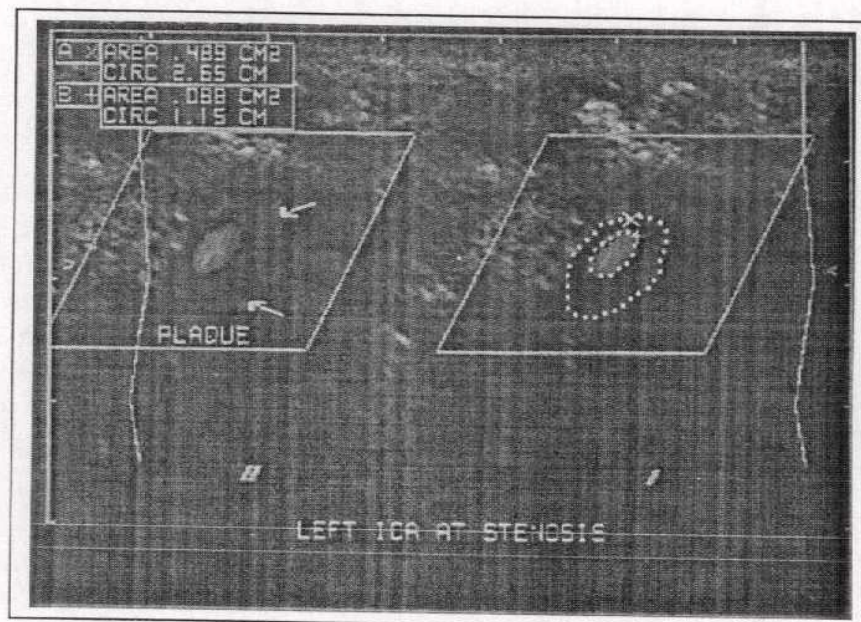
Color Doppler measurement of stenosis transverse images of a internal carotid artery. 74% (Quoted from *Zwiebel., 2000*).
